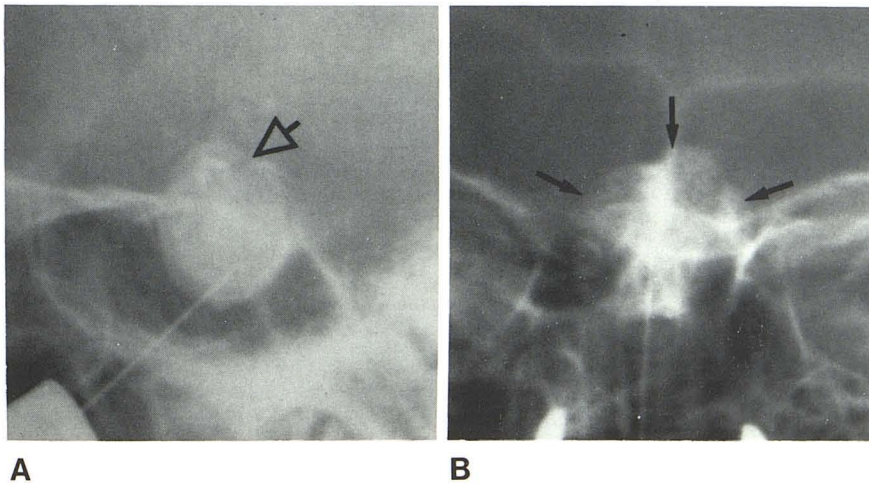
Lateral (A) and anteroposterior (B) radiographs of metrizamide injection into pituitary adenoma (arrows).
